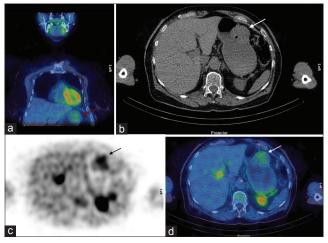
Coronal fused single photon emission computed tomography-computed tomography (a) and axial computed tomography (b), single photon emission computed tomography (c) and fused single photon emission computed tomography-computed tomography (d) images showing mild tracer uptake in the upper abdomen within a rounded, smoothly marginated mass arising from the greater curve of the gastric body (arrow)
